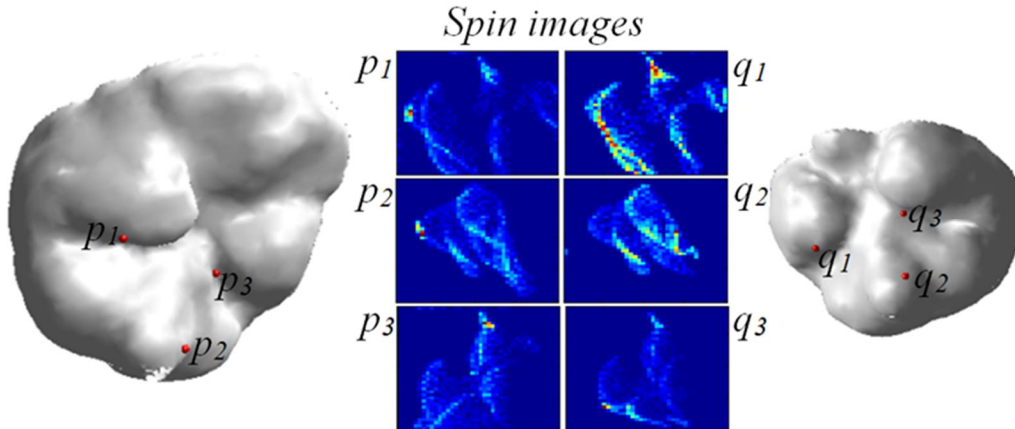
Cortical surface of reference and target intra-operative CT images. Three correspondences and their associated spin images are shown.
